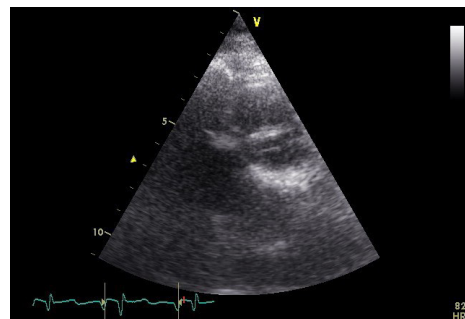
2D Echo (Modified Parasternal Short-Axis View) Indicating Bicuspid Pulmonary Valve.
